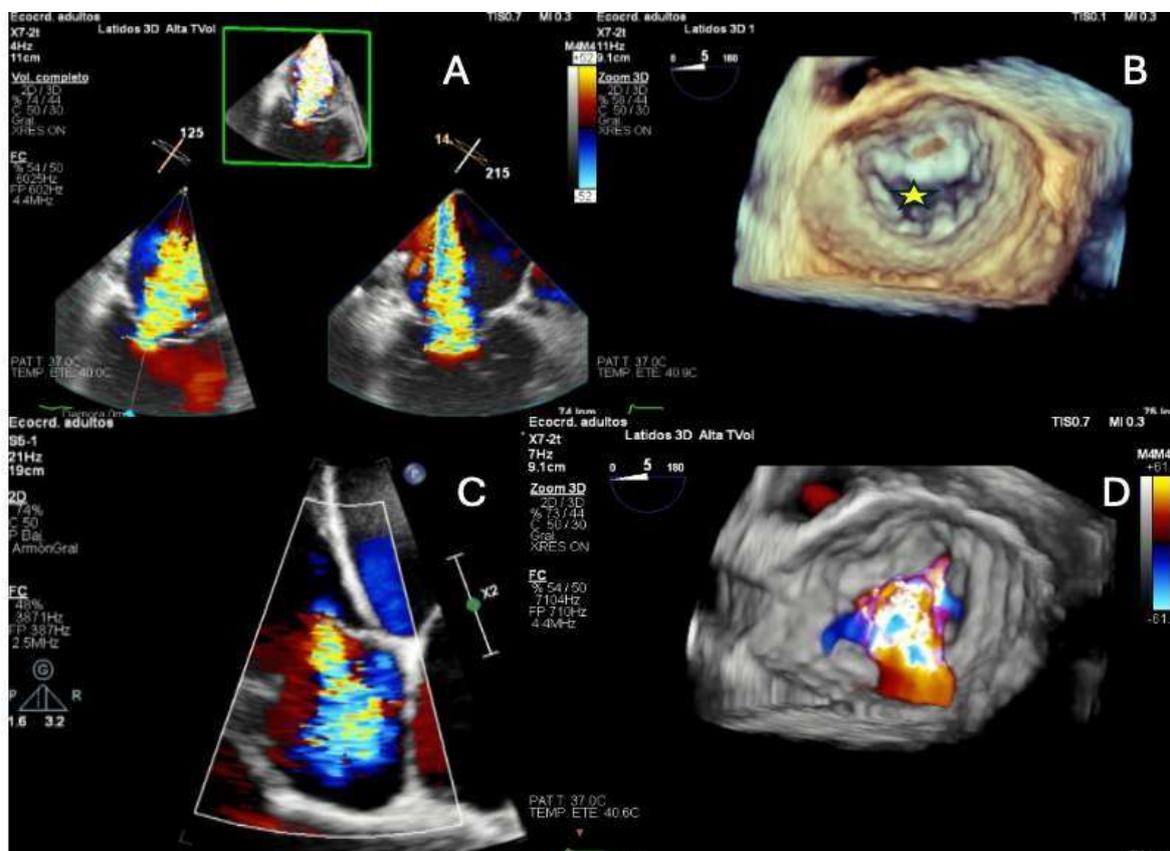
Echocardiographic assessment of severe atrioventricular valve regurgitation.
